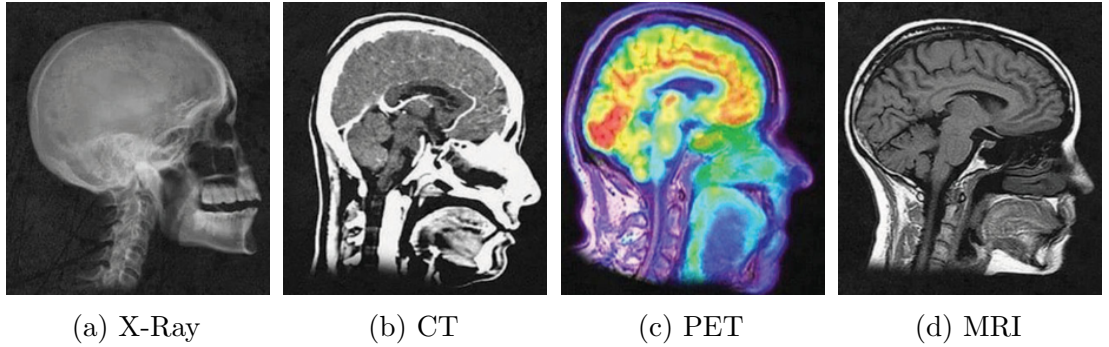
The sagittal brain images from X-Ray, CT, PET, and MRI (Kshatri et al. 2023).
